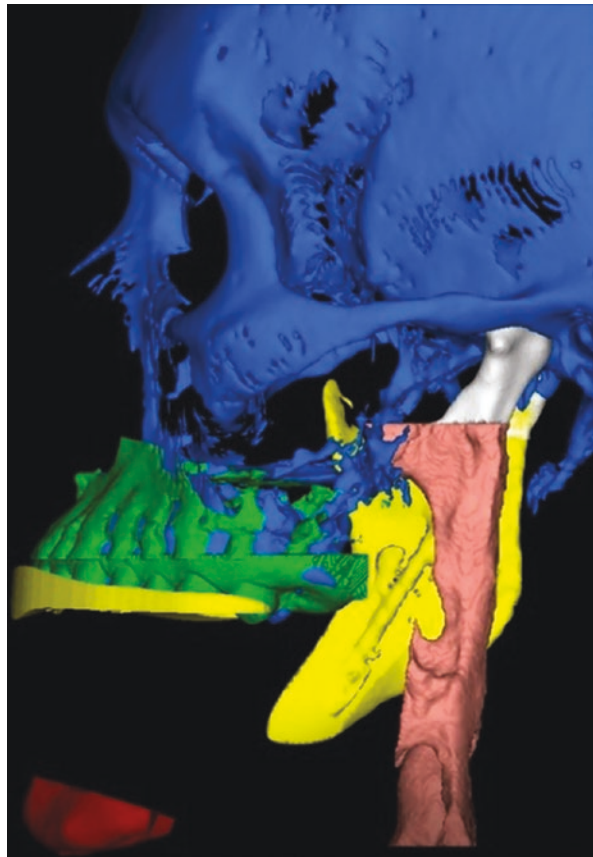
Linear and volumetric airway measurement in cone beam tomography
